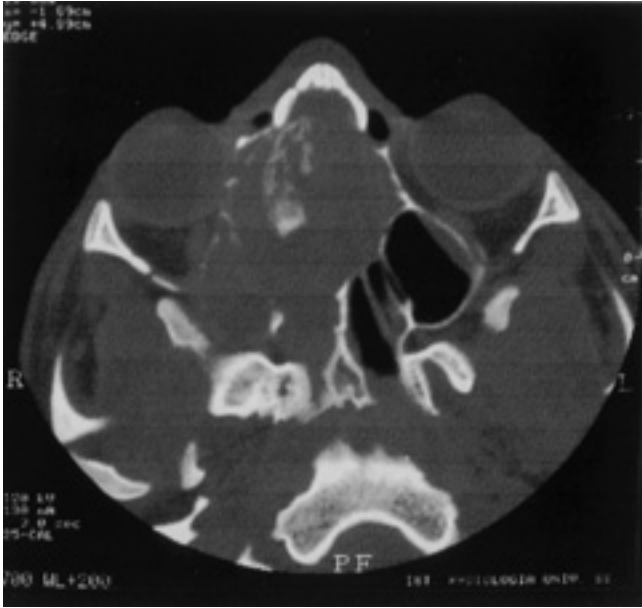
In the axial cut all right paranasal cavities are occupied by a neoplasm with soft tissue CT density.
